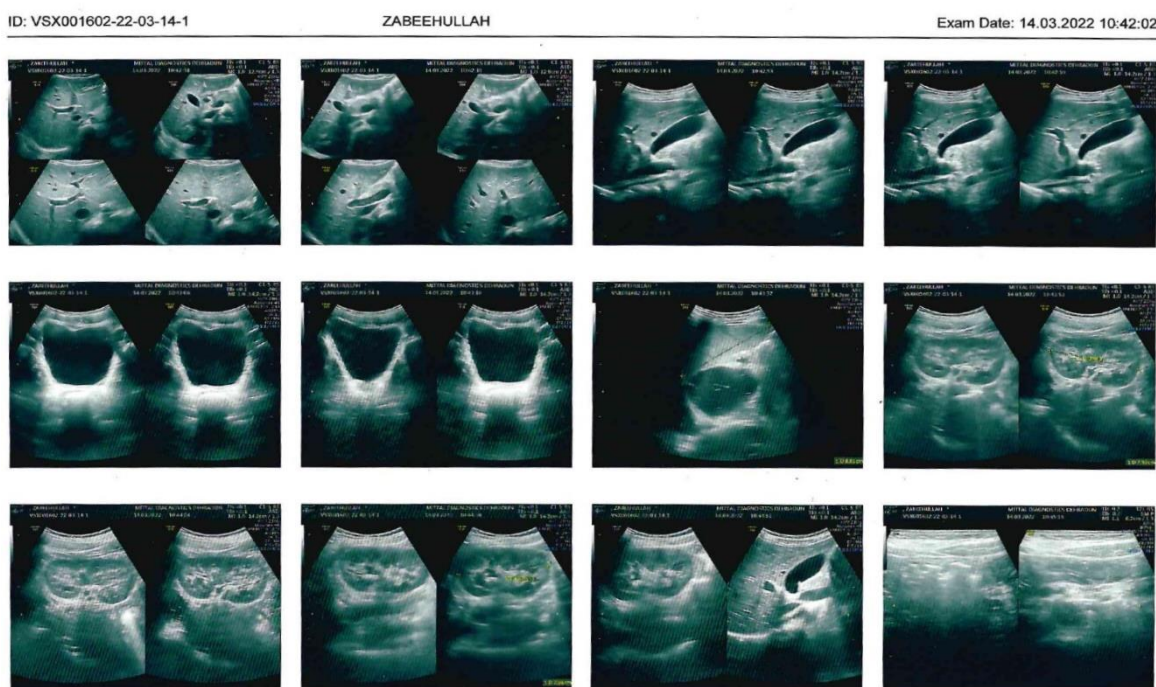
2 – Ultrasonography of postoperative phase shows no wall thickening
